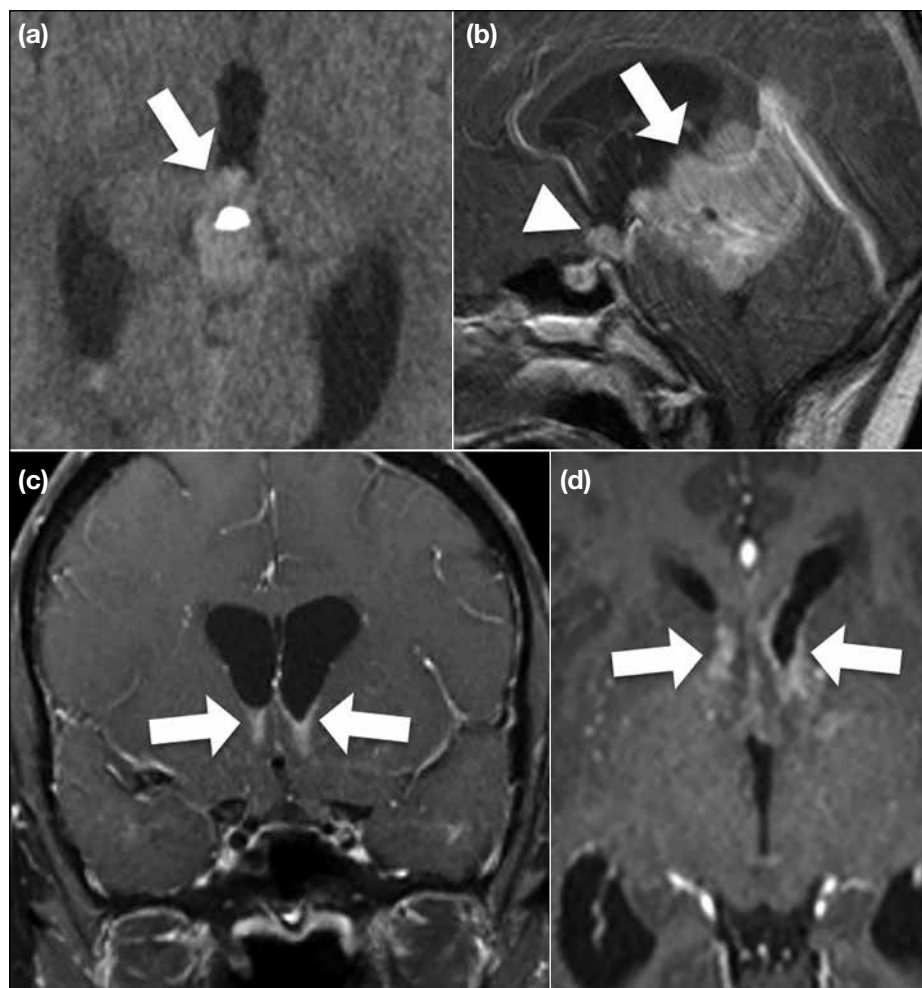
Germinoma. Case 1 (a) showing engulfment of the pineal calcification by a pineal germinoma (arrow) on axial nonenhanced computed tomography image. Case 2 (b) showing doublet germinoma lesions with a larger pineal component (arrow) and a smaller suprasellar component (arrowhead) on enhanced sagittal T1-weighted fat-suppressed image. Case 3 showing a rare presentation of a germinoma with bilateral enhancing frontal horn wall infiltration (arrows) on coronal (c) and axial (d) T1-weighted fat-suppressed images.
